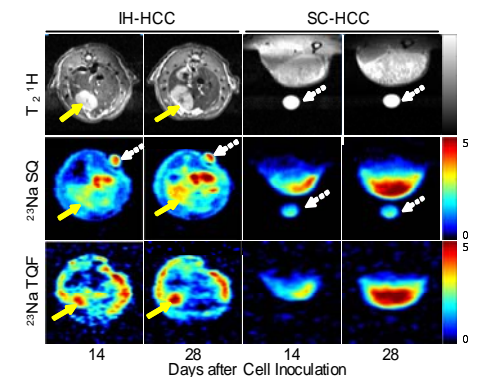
DWI ¹H, SQ and TQF ²³Na MRIs of IH and SC HCCs 14 and 28 days after N1S1 cell inoculation. IH-HCCs are marked by yellow arrows and the references are marked by the dotted white arrows.
